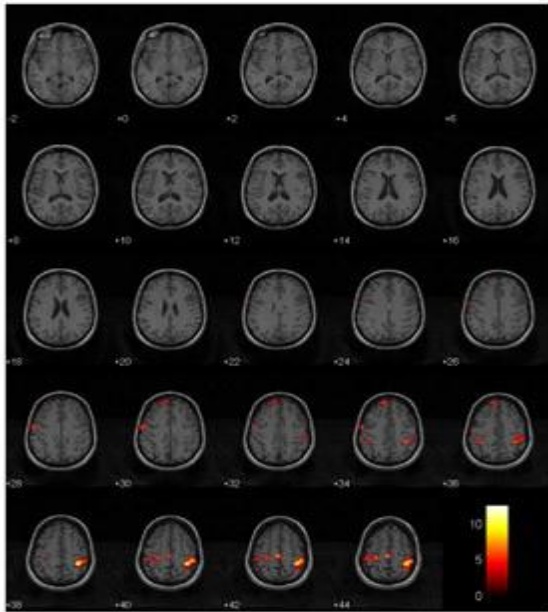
Functional Magnetic Resonance Image of brain [6]
